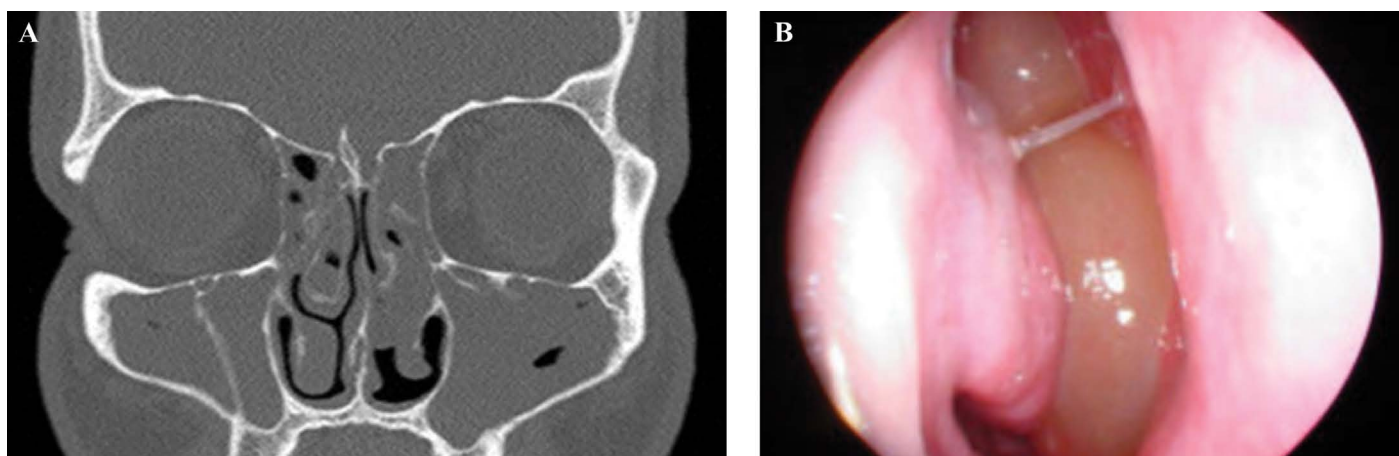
CT scan of paranasal sinuses in frontal projection. Extensive polypoid lesions filling the maxillary and ethmoid sinuses as well as middle and superior nasal meatus. The patient was qualified for ESS surgery (A). Polypoid lesions filling the ethmoid cells and the superior and middle nasal meatus visible in nasal endoscopy (B).
